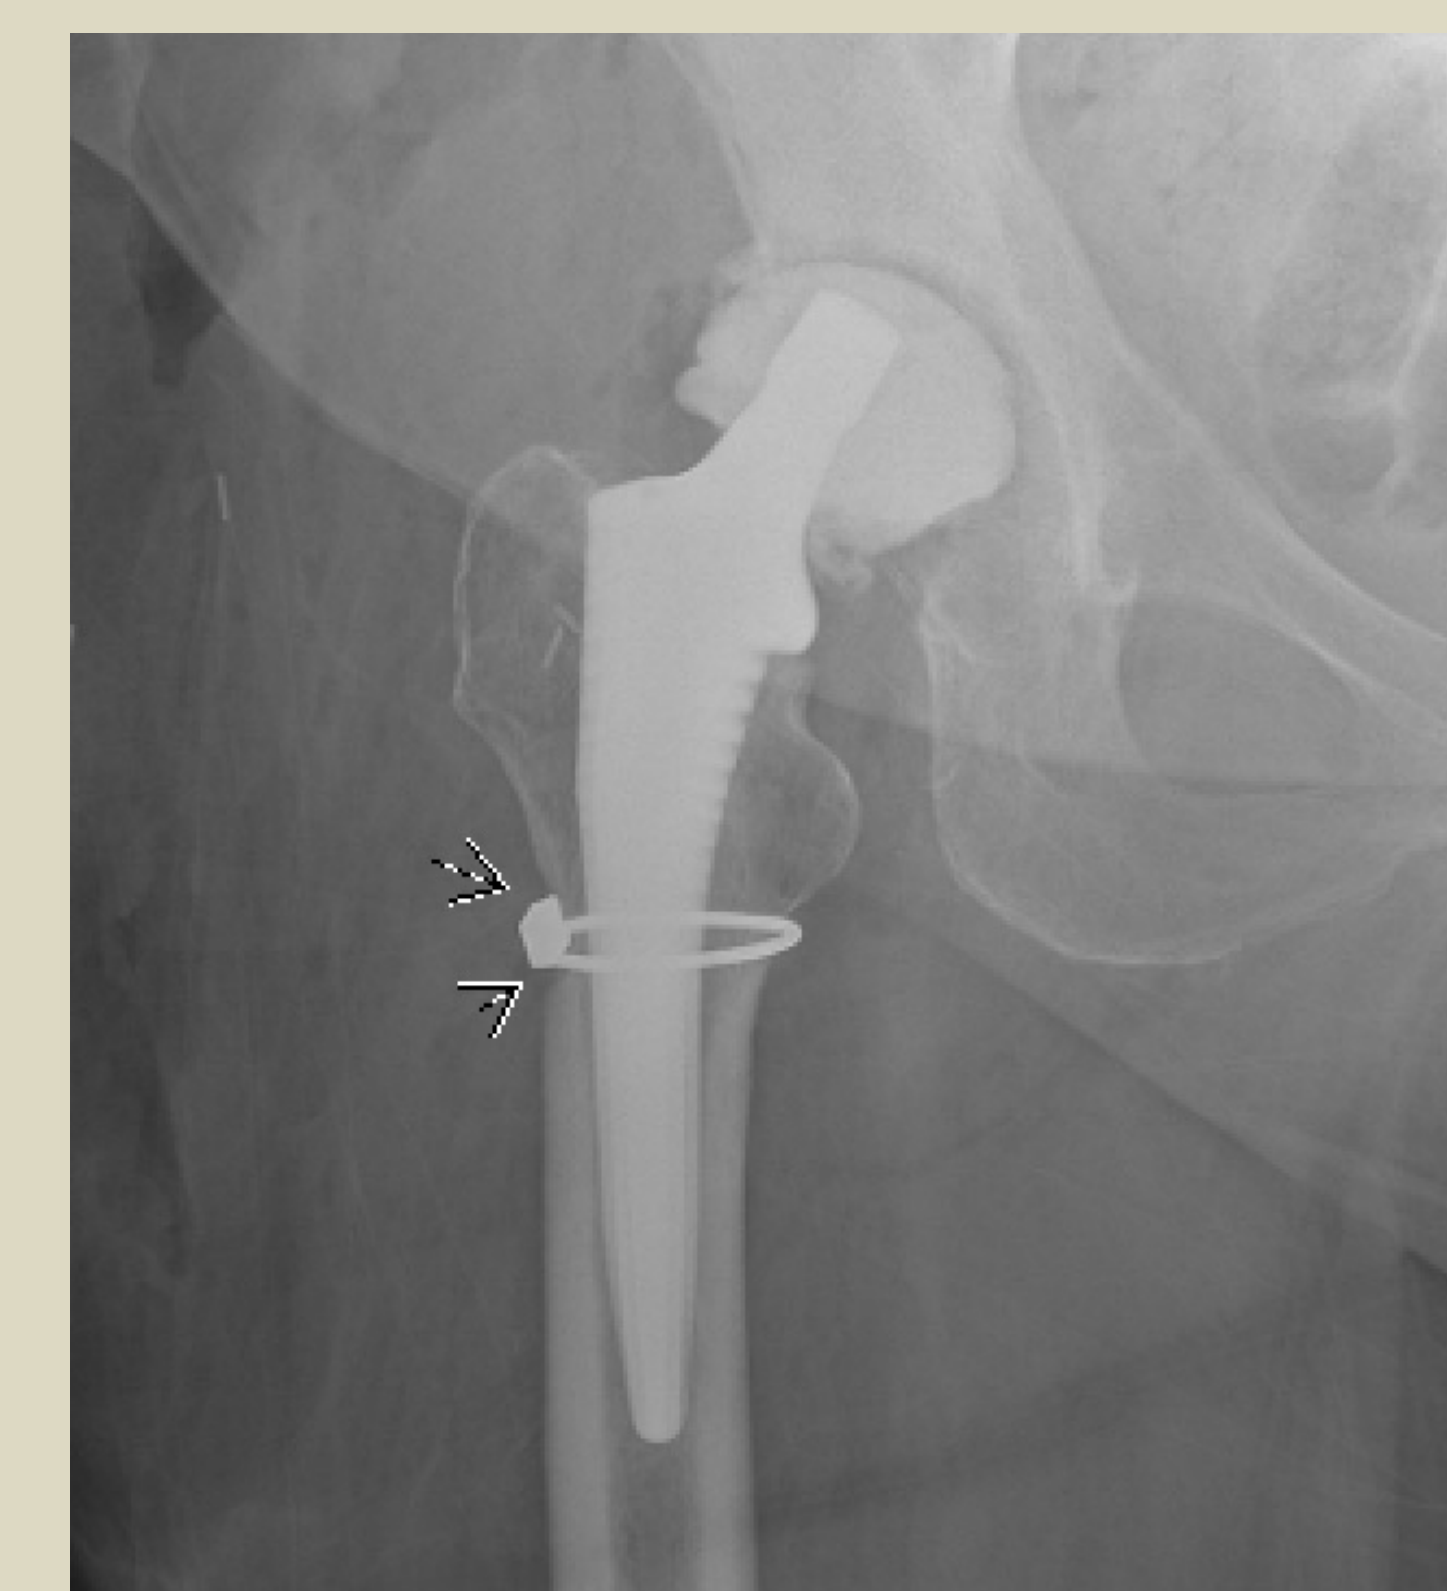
X-ray of post-surgical changes following staged THA revision with antibiotic spacer.
